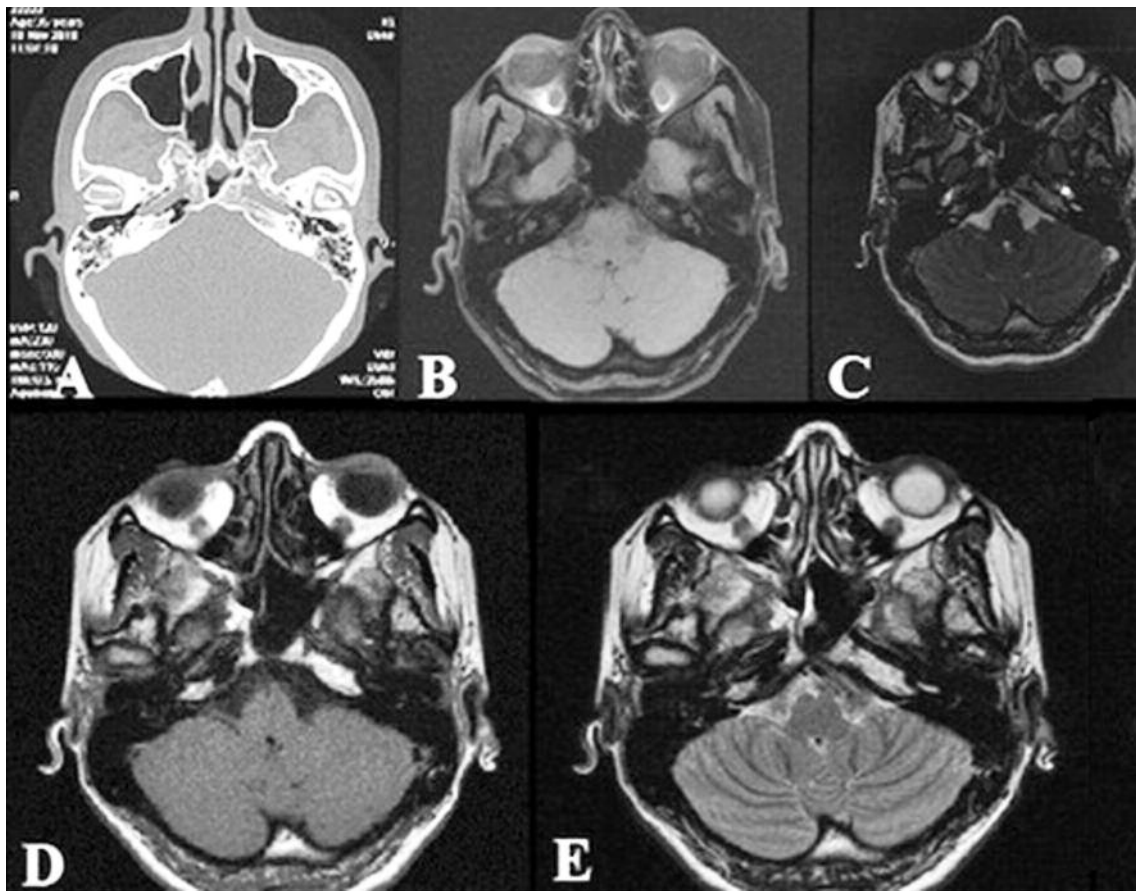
Asymmetric bone marrow in the left PA. A: Axial CT shows nonexpansile isodens lesion without any trabeculation lost; B: FAT SAT T1 WI shows loss of hyperintense characteristic after fat saturation; C: FIESTA shows lesion isointens with retroorbital fat tissue; D: Axial T1 WI shows a hyperintense lesion; E: Axial T2 WI shows hyperintense lesion.
